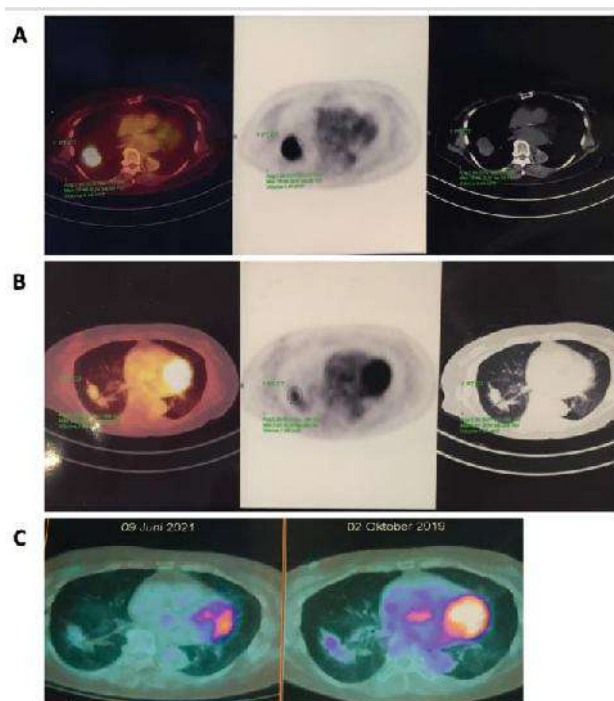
A) FDG-PET-CT scan in 2018 showed pulmonary mass with enhanced uptake; B) PET-CT scan taken 1 year later show stable disease; and C) PET-CT scan after 3-years therapy showed decreased mass with fibrotic loci and no metabolic activity.
